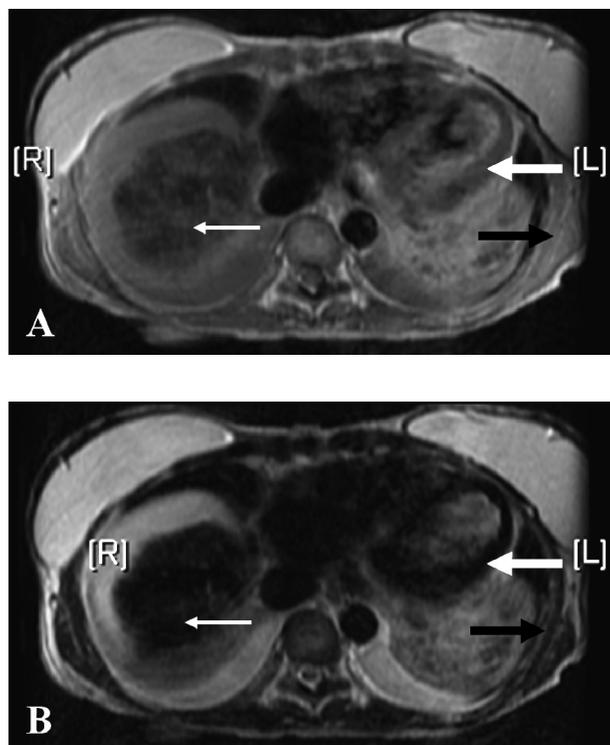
A. T1-weighted, SE image in axial plane. Attenuation of signal in left ventricular myocardium (large white arrow) and superior pole of liver (small white arrow) suggests iron deposition in contrast with signal for skeletal muscle (black arrow). T1-weighted sequence obtained with double inversion recovery SE: TE 20, echo trail length (ETL) 32, bandwidth (BW) 62.5, FOV 36, matrix = 256×256 . B. T2-weighted, SE image in identical axial plane as Fig. 1A. Significant signal attenuation is seen in myocardium, as compared to skeletal muscle. This T2-weighted sequence obtained with double inversion recovery SE: TE 80, ETL 32, BW 62.5, FOV 36, matrix = 256×256 .
